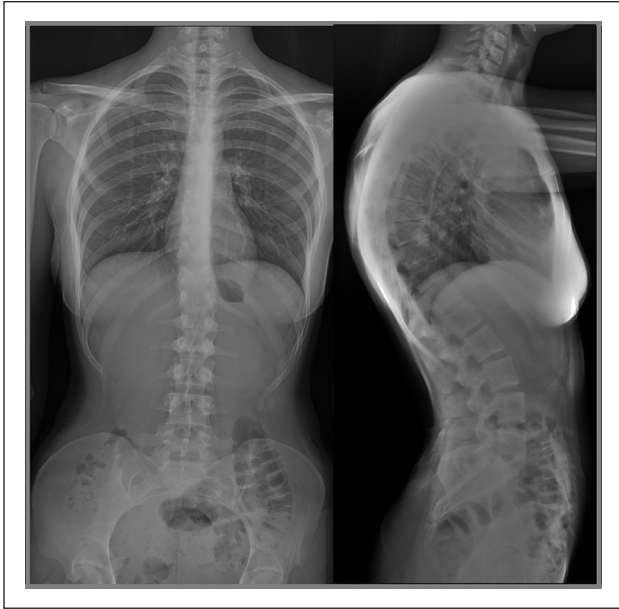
Radiographs of a 19-year-old female patient with type I SD. The thoracic kyphosis measures 78°, with an apex at T8.
